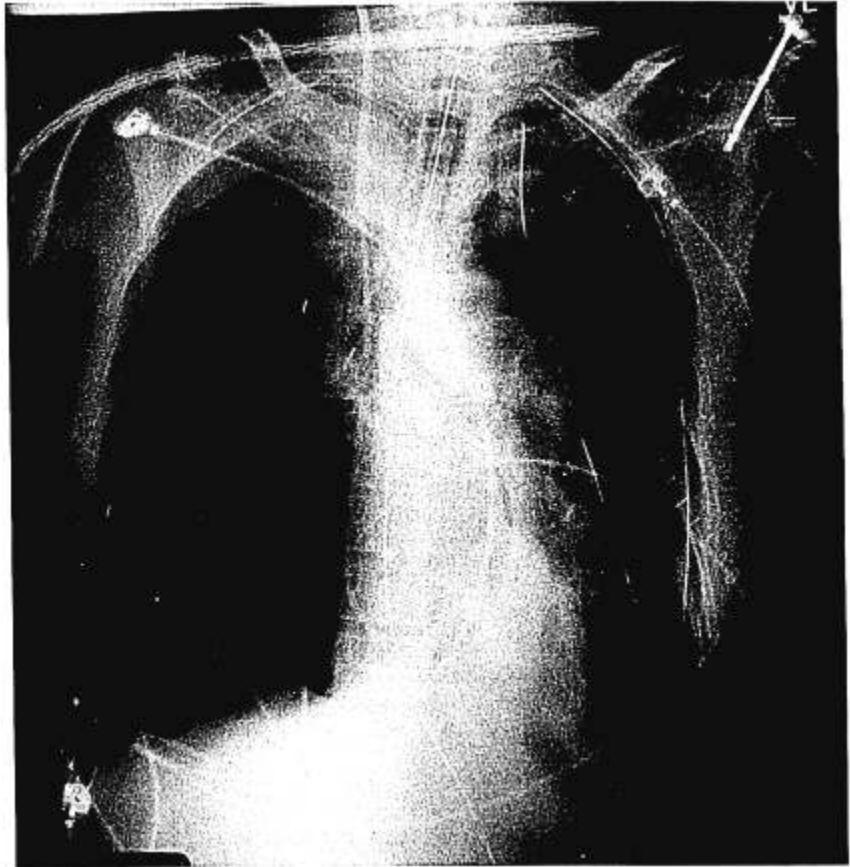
Immediate postoperative portable frontal radiograph of chest. A right-sided double lumen endobronchial tube extends down the right main bronchus, and the right upper lobe is collapsed.
